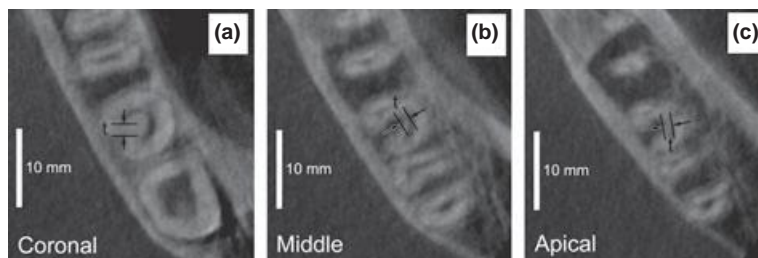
Example of cone-beam computed tomography axial images of a tooth with C-shaped canal configuration. (a) coronal third level, (b) middle third level, (c) apical third level.
